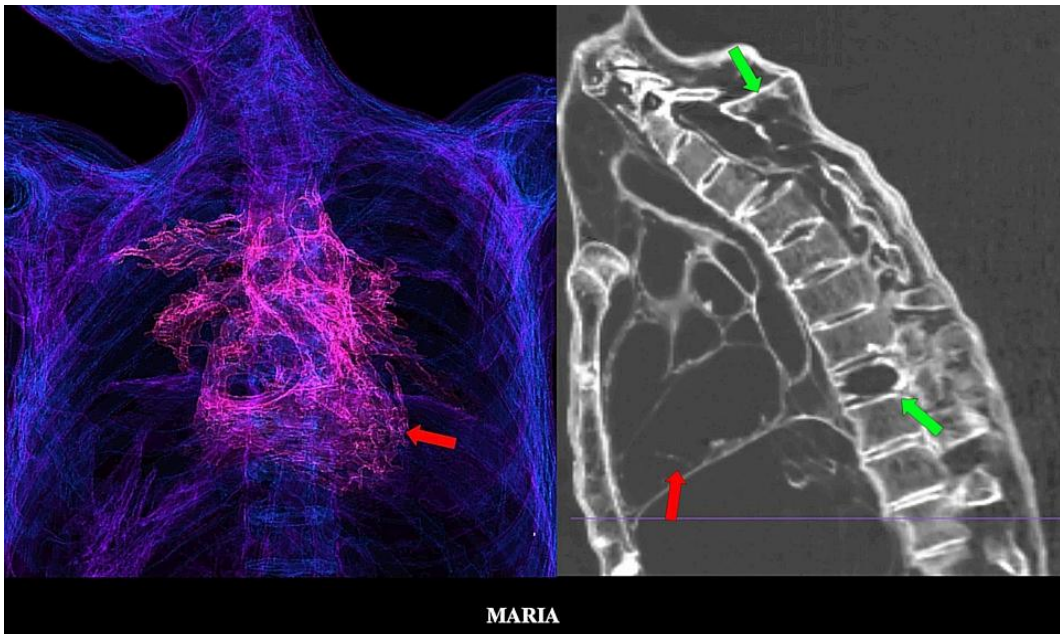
3D CT showing the scaffolding of the heart (*red arrows*) showing normal shape. Destructive bone lesions can be identified in spine (*green arrows*).
